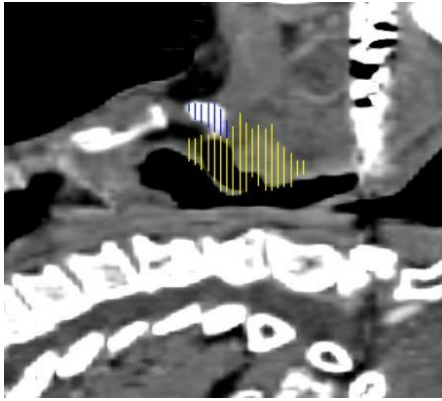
Patient B: planning CT.
